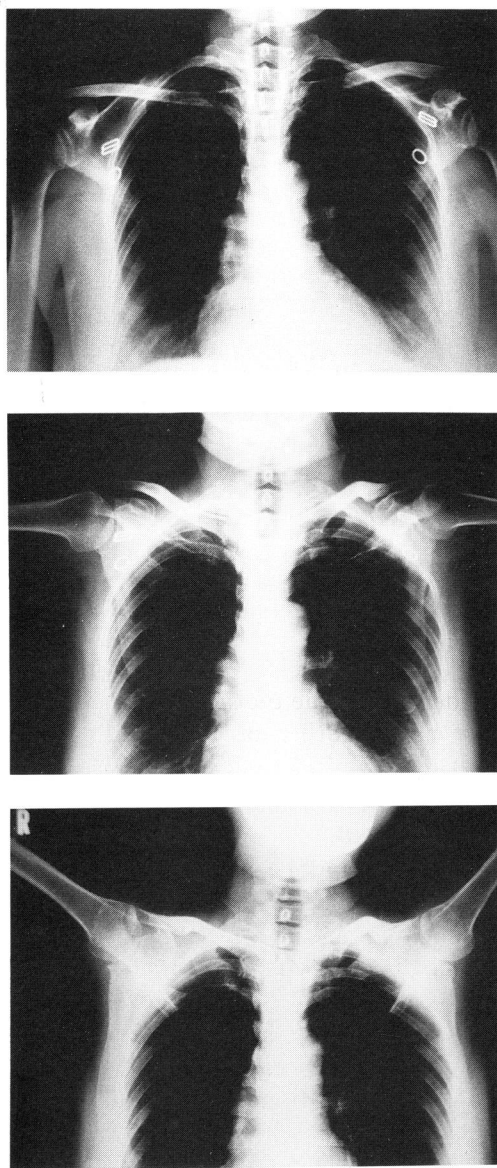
Anteroposterior radiographs of the both arms, showing sequential changes of the bones at (A) the arms in the resting position, (B) elevation of the arms to 90°, and (C) elevation of the arms above the head.
